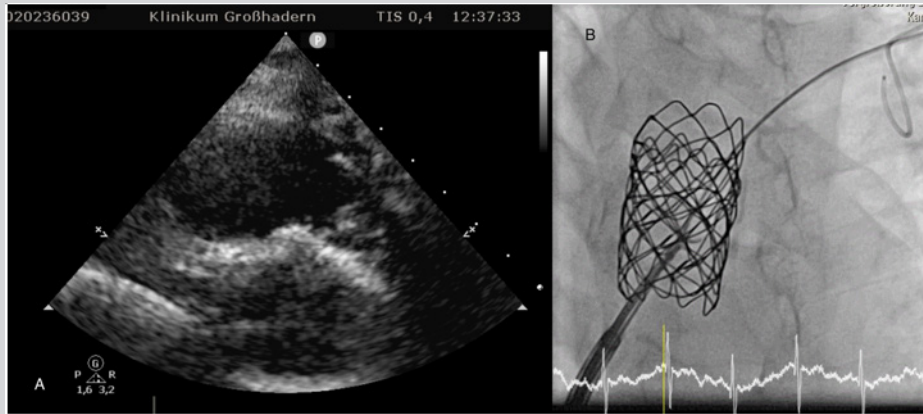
A. Echocardiographic picture with the thickened and obstructed Melody® valve and a gradient of > 50mmHg.
